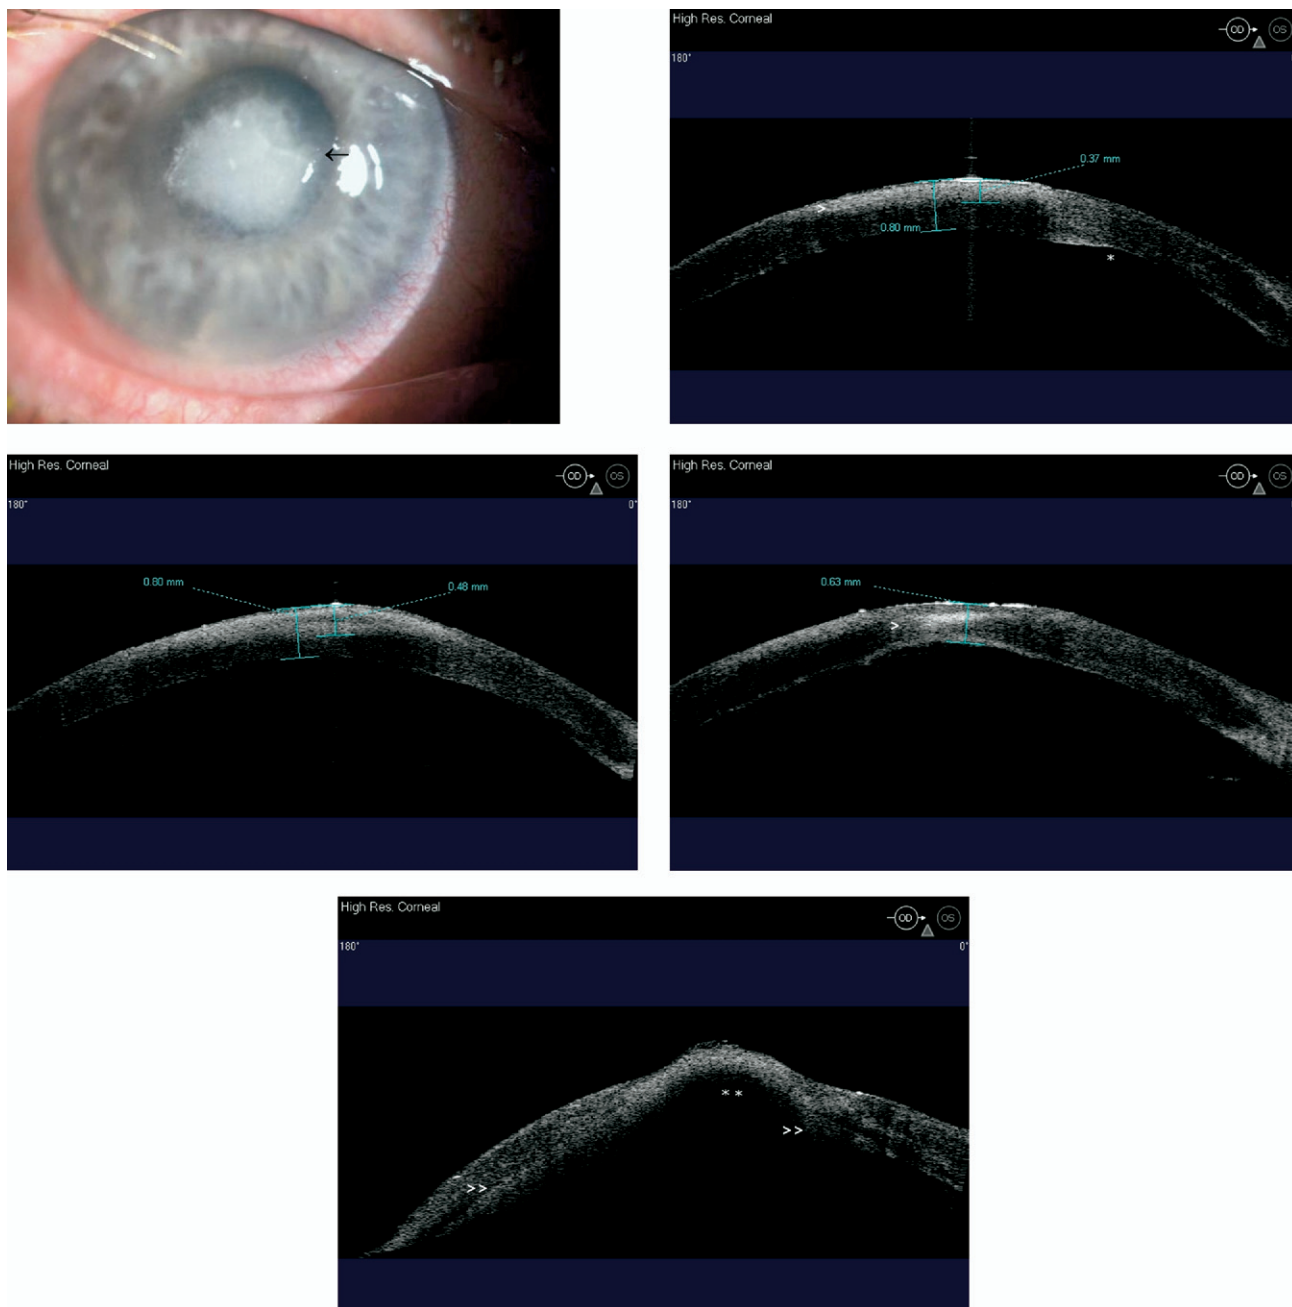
Images demonstrating fungal keratitis in a contact lens wearer, including serial high-resolution AS OCT images at the 180-degree meridian. (Top left) Anterior segment photograph obtained at presentation showing dense corneal infiltrate (arrow). (Top right) AS OCT image obtained at presentation showing anterior stromal infiltrate (>) and edema resulting in change in curvature of posterior corneal surface (*). (Middle left) AS OCT image obtained four days after presentation showing an increase in infiltrate thickness. (Middle right) AS OCT image obtained seven days after presentation showing further increase in infiltrate thickness (>) and reduction of CT. (Bottom) AS OCT image obtained two weeks after presentation showing corneal thinning with descemetocoele formation (); inflammatory plaque can be seen attached to endothelial surface (>>).
